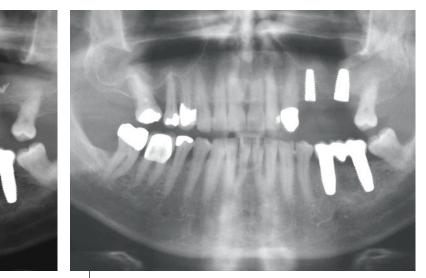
OPG (Orthopantomogram) after implantation.
